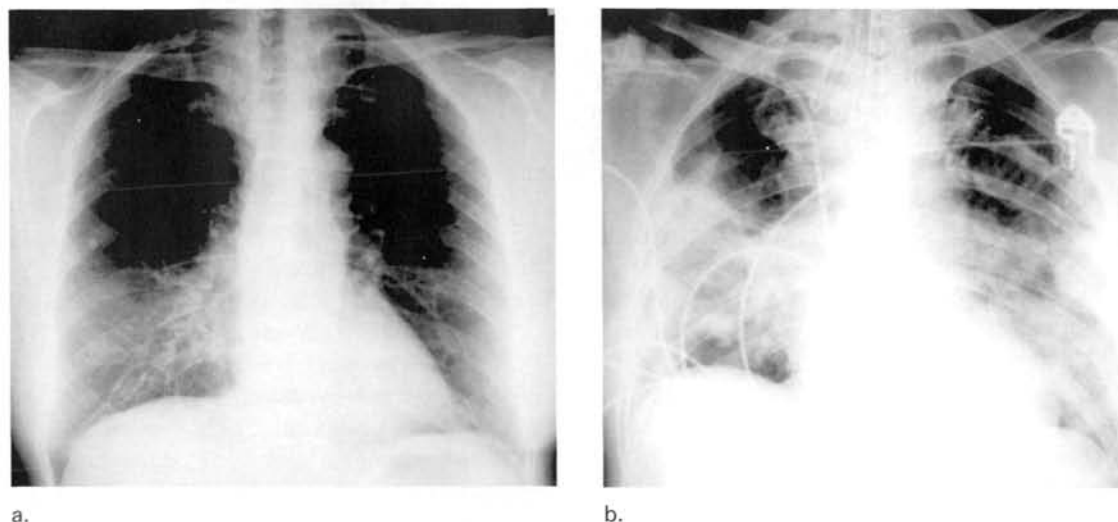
Chest radiographs of a 45-year old female with SARS showing (a) ground glass opacification in the right lower lobe that progressed to (b) multifocal patchy consolidation within 4 days.
